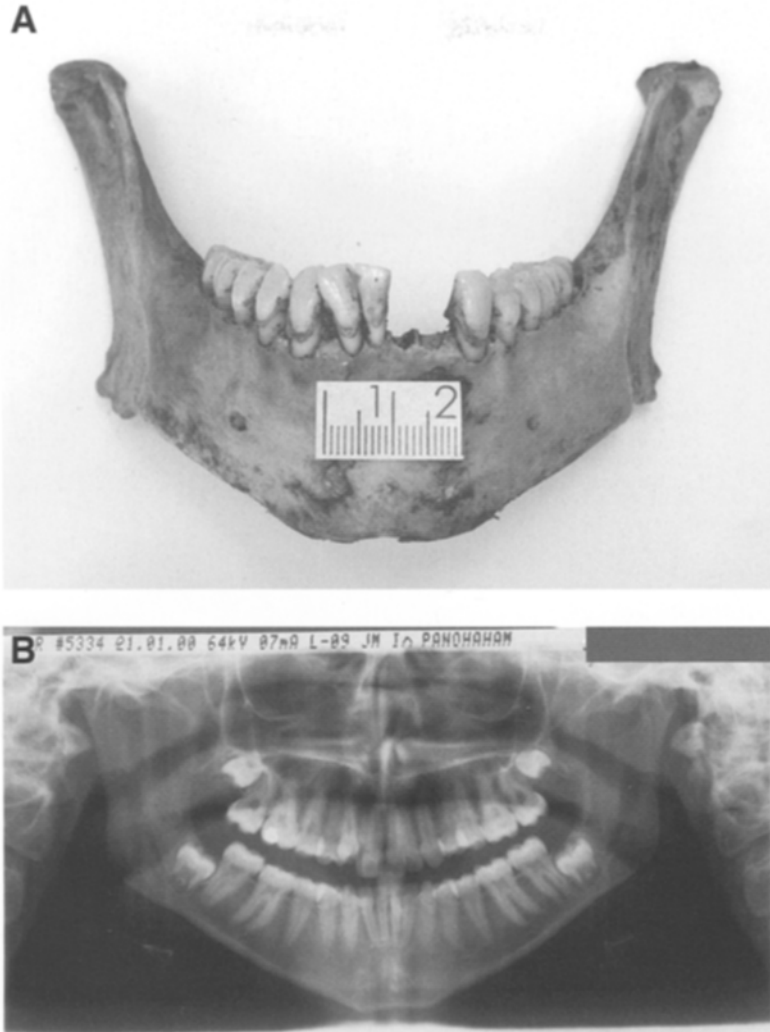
(A) Human mandible encountered in the woods near the area where a 19-year-old woman had disappeared 2 years before. (B) Orthopantomogram of the missing woman taken when she was 16 years old. Note the unerupted mandibular third molars. (C) Periapical radiograph of the left mandibular third molar. Note the position of the impacted tooth, which rules out the possibility of this being the mandible of the missing woman because during the time elapsed between the antemortem radiograph and her being missing, the tooth could have not rotated to the present position underneath the bulge of the second molar.
